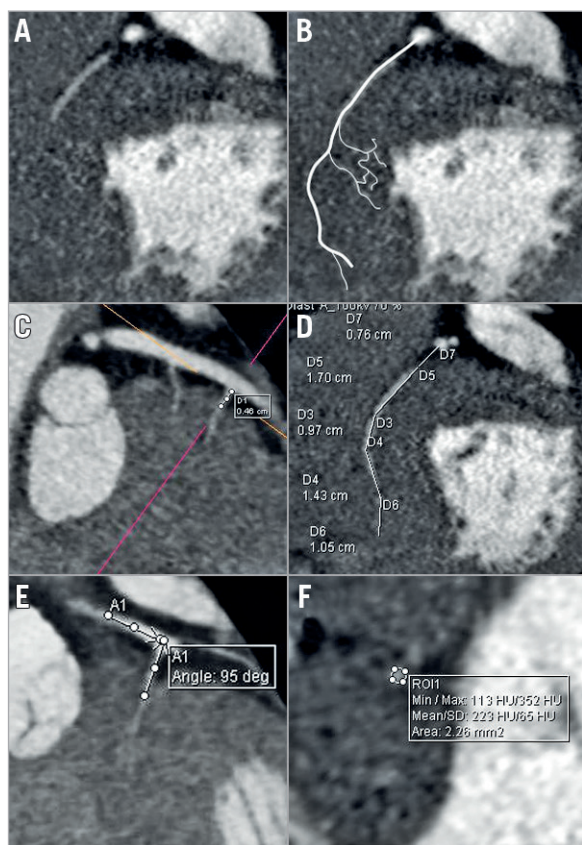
Anatomical details taken from 2D CT images. A) Short-axis view at the level of target myocardium. A septal artery was seen and highlighted (B). C) Septal vessel with a measurement of the distance travelled from parent vessel to entry into the myocardium. D) Total length of septal vessel from ostium. E) Angle of entry from LAD into septal. F) Area of septal vessel.
